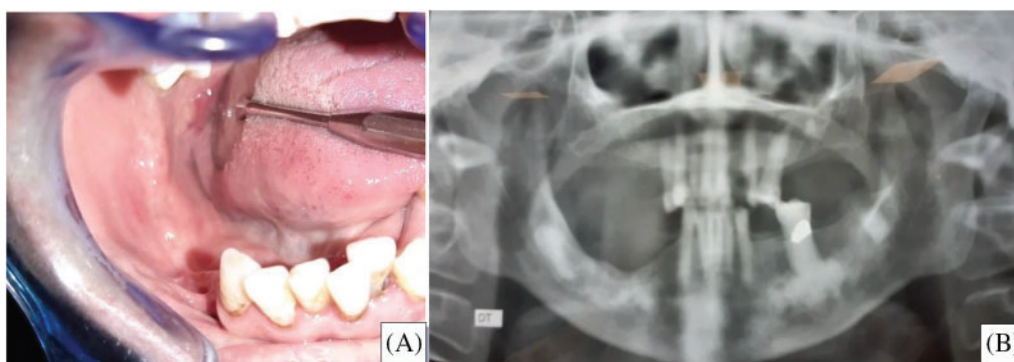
A) intraoral view showing mucosal healing at week 22 and B) the panoramic radiography revealed bone healing at week 22.
